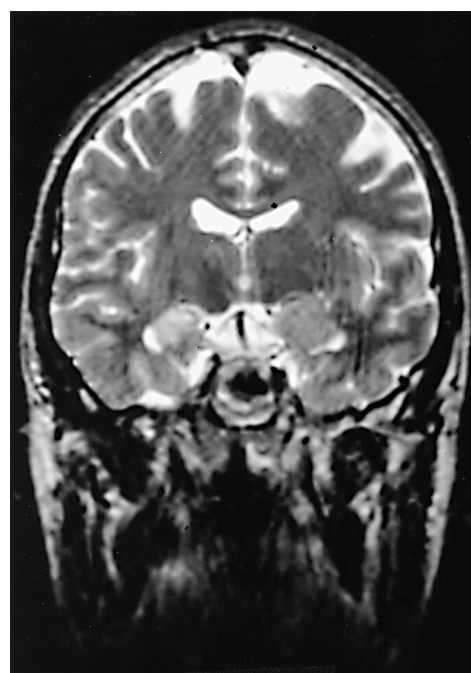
Axial magnetic resonance image of patient pre-radiosurgery. Note right medial temporal lobe sclerosis with increased T2 signal, typical of long-term epilepsy.
